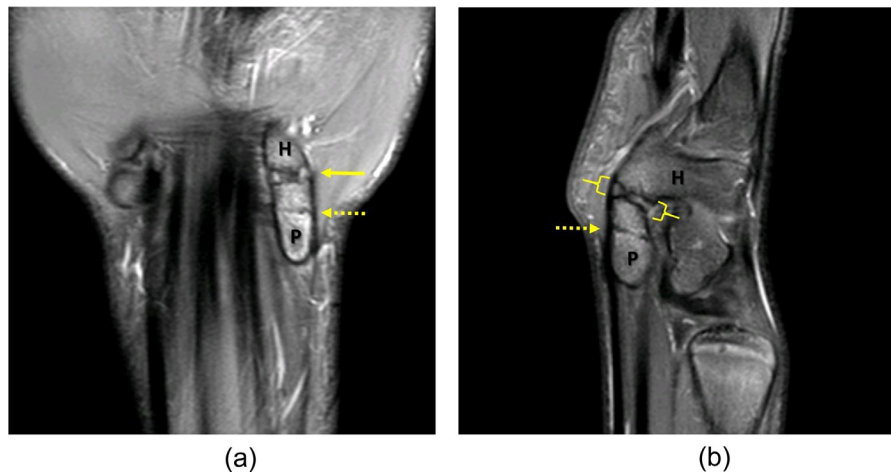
(a) Coronal fat-saturated proton density magnetic resonance images demonstrate the fibro-cartilaginous coalition (solid yellow arrow) between the hamate (H) and the pisiform (P), the transverse minimally displaced fracture through the mid body of the pisiform, and the marrow edema involving the hook of the hamate and the pisiform. (b) Sagittal fat-saturated proton density magnetic resonance images demonstrate the fibro-cartilaginous coalition (yellow brackets) between the hamate (H) and the pisiform (P), the transverse minimally displaced fracture through the mid body of the pisiform, and the marrow edema involving the hook of the hamate and the pisiform. (Color version of figure is available online.)
